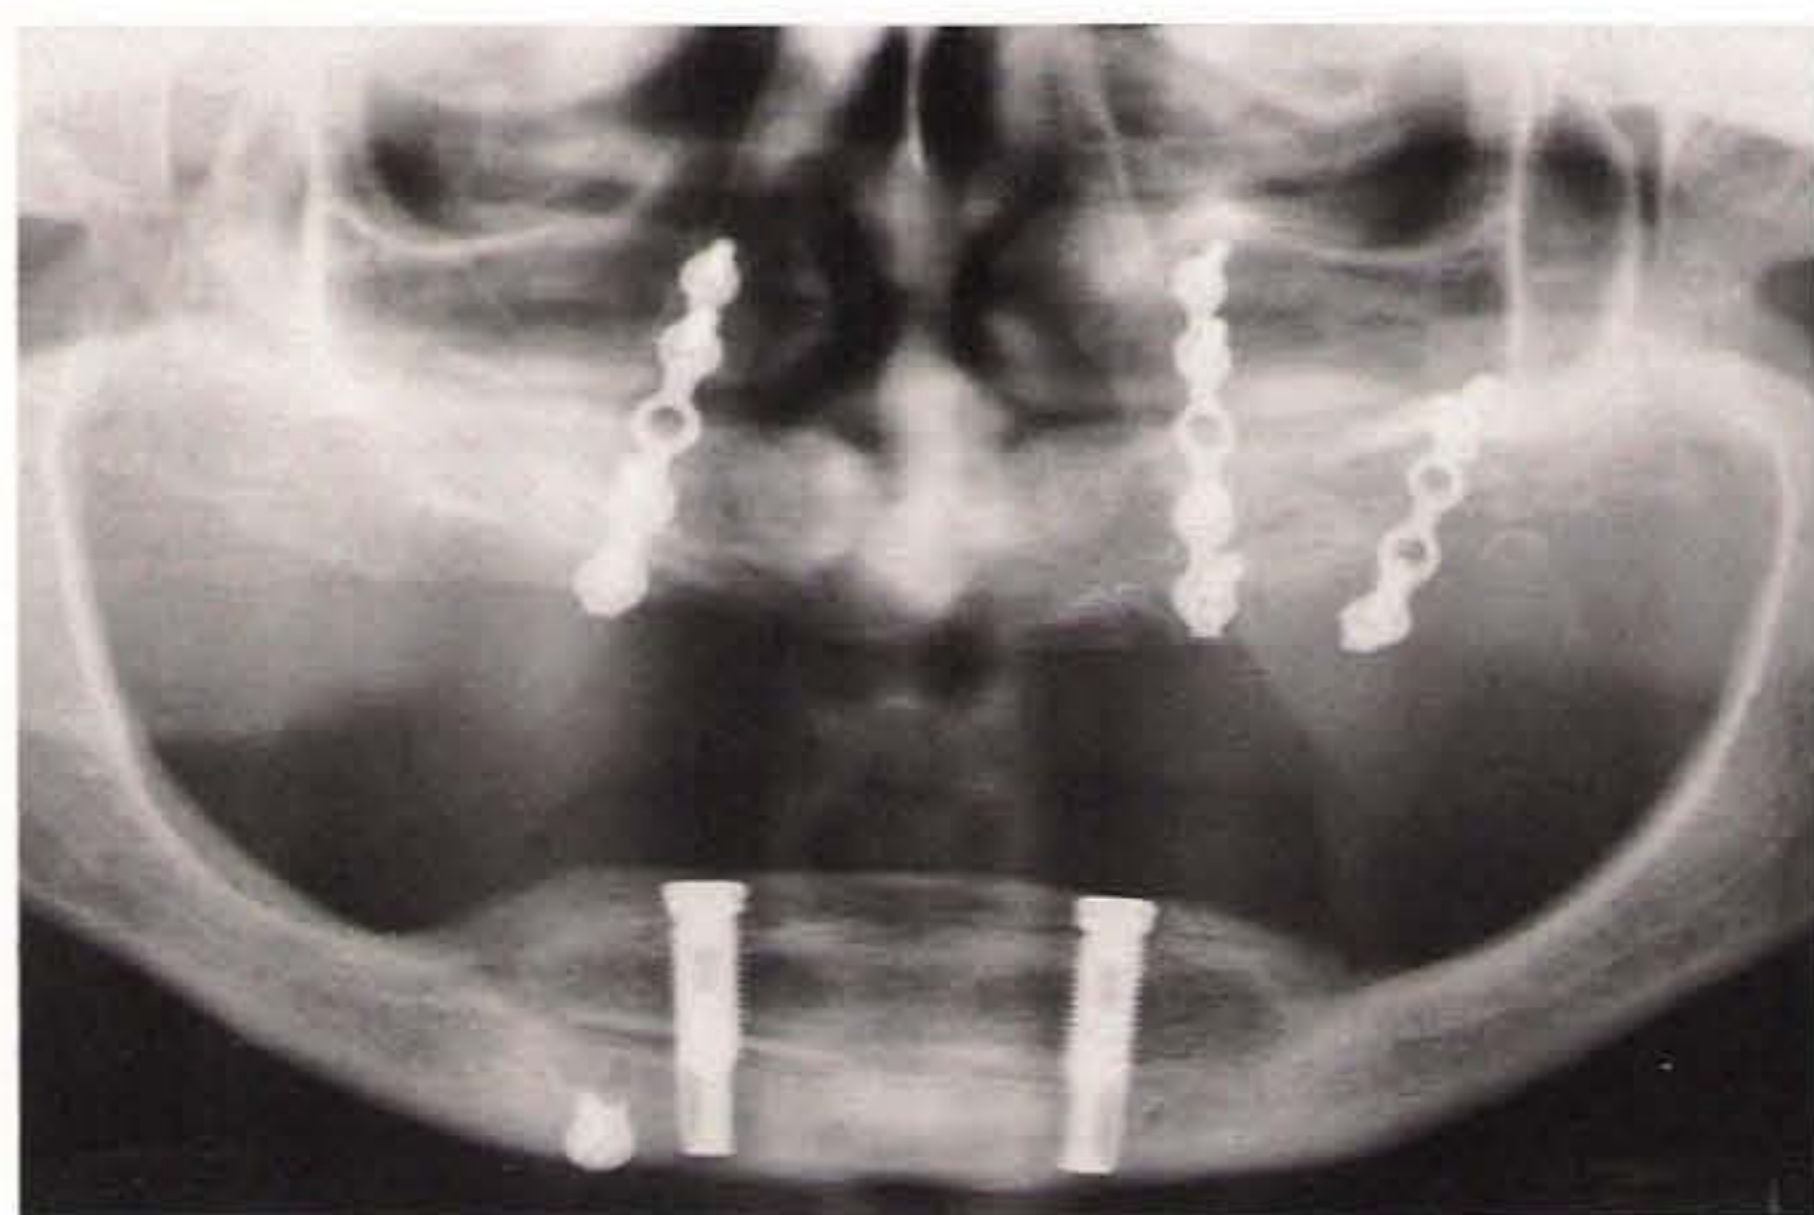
Control panoramic radiograph taken after positioning of two Brånemark implants in a case of inlay bone grafting. (Courtesy of Dr Flavio Mela.)
